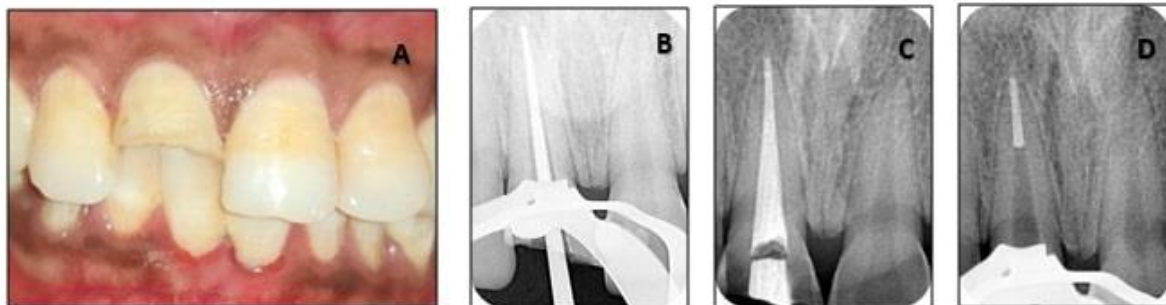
Case-1 Root canal therapy A: Pre-operative clinical photograph showing Ellis class III fracture - #11 B: Master cone radiograph C: obturation radiograph D: Post space preparation radiograph.
